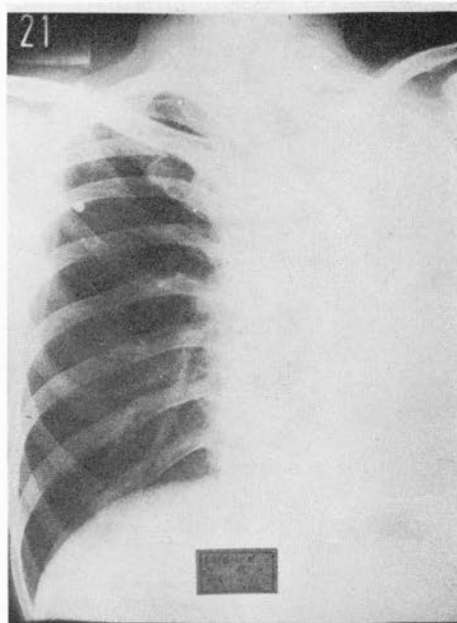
Postoperative Chest Roentgenogram.
